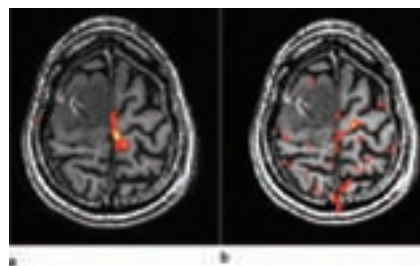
Functional MRI. Pre-operative study for planning of right superior frontal tumour resection. The patient has been given the task of toe movement. a) Axial image, patient moving right toe. There is activation in the medial left precentral gyrus. b) Axial image, patient moving left toe. Activation is more diffuse and bilateral with some activity seen on the periphery of the right frontal tumour.
